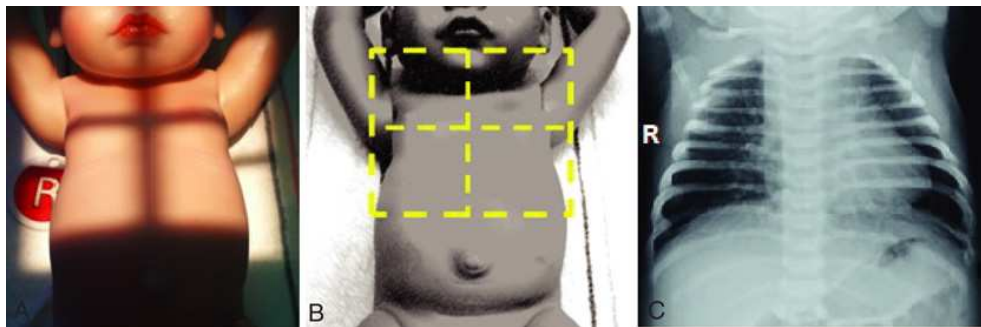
(A) AP chest, central ray directed to nipple line. (B) AP chest, radiation light field. (C) AP chest radiograph.
